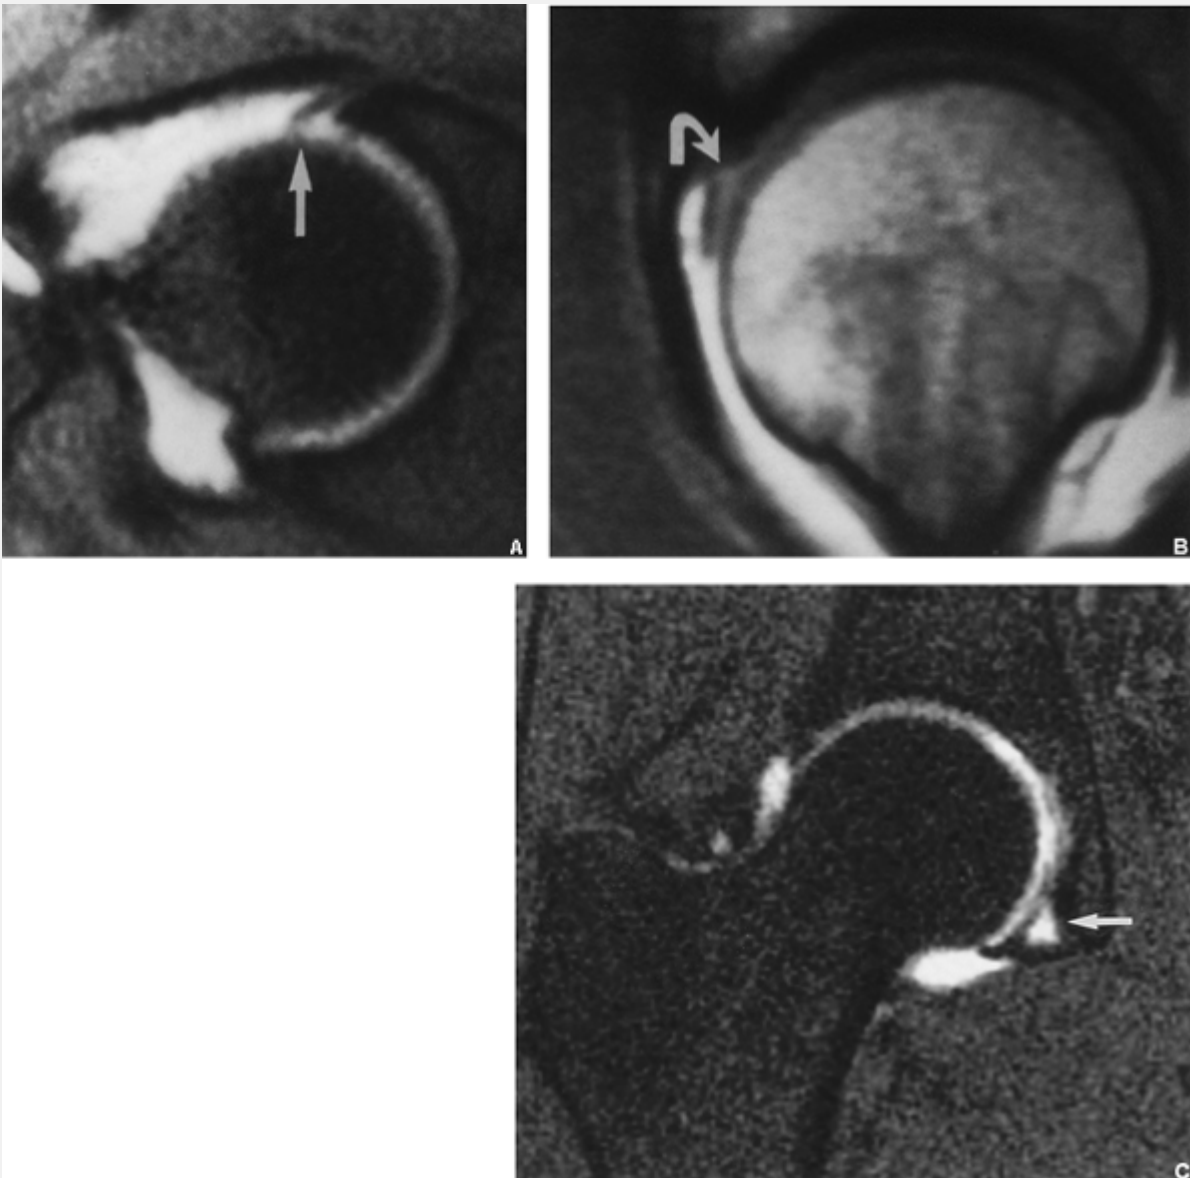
MRI of normal acetabular labrum. Coronal fat-suppressed T1-weighted MR arthrographic image shows a normal appearance of the acetabular labrum (*arrow*). Note the triangular shape, smooth contour, and low signal intensity of this structure. [Reprinted with permission from Steinbach LS, Palmer WE, Schweitzer ME. Special focus session. MR arthrography. *Radiographics* 2002;22:1223–1246].
